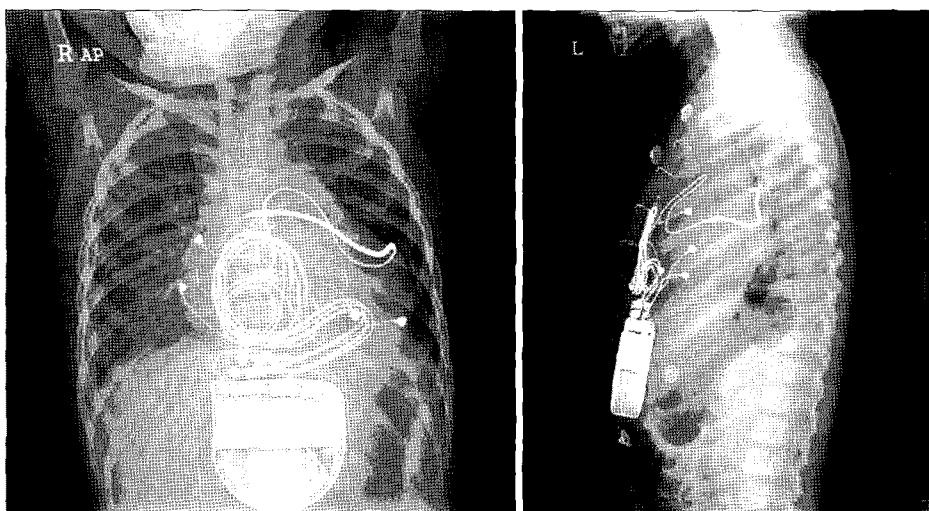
Chest X-rays showing adequately positioned coil, electrodes and the ICD generator.
